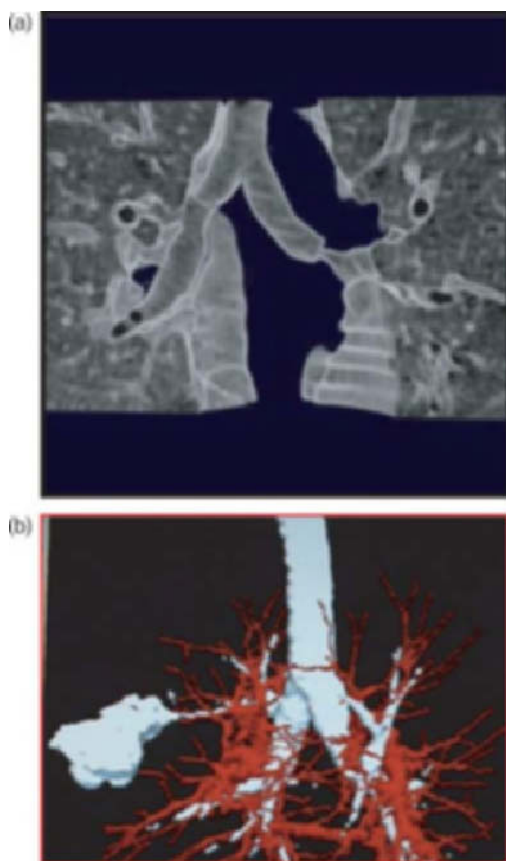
Three dimensional reconstruction of a thorax CT and rendering of the central airways demonstrating a postoperative stenosis at the site of an anastomosis (a). (Courtesy A. Ernst, Beth Israel Deaconess Hospital, Boston, MA, USA.) On virtual bronchoscopy the path leading to a peripheral lesion is calculated by rendering the pulmonary vessels and the bronchial tree (b). (Reproduced with permission from German Cancer Research Center, Heidelberg, Germany.)
